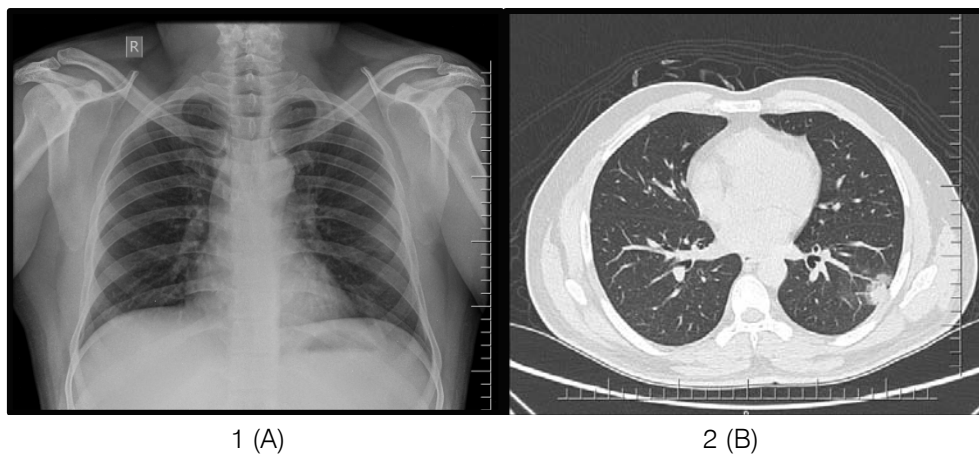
Chest radiograph showing subtle left lower zone infiltrate. Computed tomography image showing Halo sign
